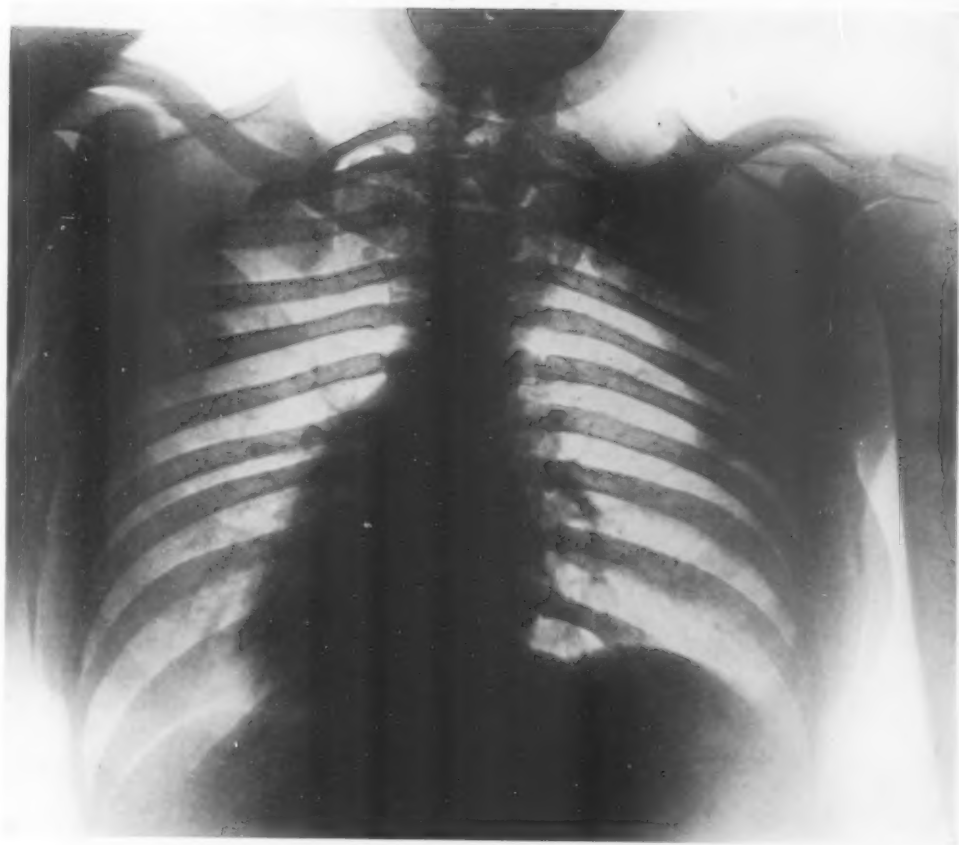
Reproduction from stereoscopic X-ray plate showing anomalous bony plate, cervical rib and spina bifida. Plates taken in supine position.
